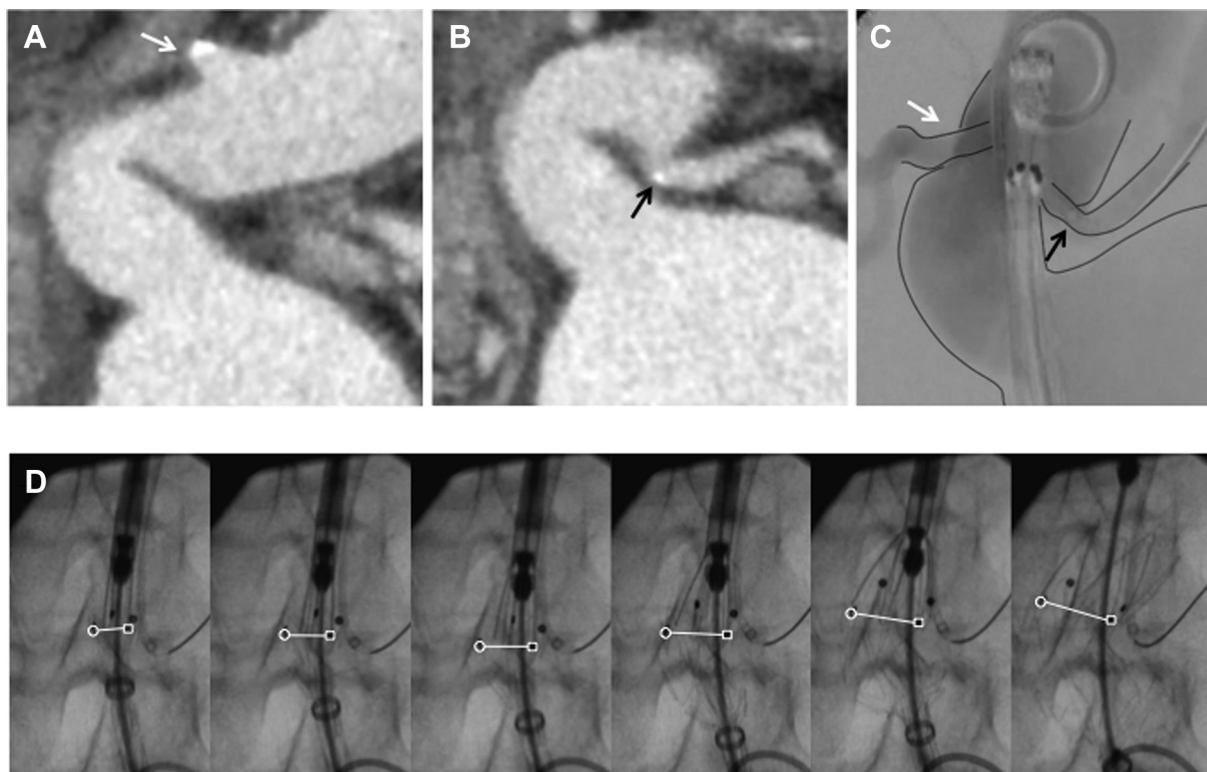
Deployment of the Endurant stent graft with the reverse slider technique in the angulated neck case (case 1). A and B, Preoperative three-dimensional computed tomography images show a severely angulated neck at 130 degrees with neck length of 25 mm. C, Angiography during the procedure. The Endurant delivery system runs on a shortcut. It touches the lower left renal artery in the lesser curvature side. D, A series of photographs until the suprarenal stent release. The top edge of the graft fabric on the greater curvature side is deployed and kept in the upper position. The *open circles* indicate the e mark stitched on the graft fabric edge. Each *open square* indicates the o mark stitched on the contralateral side of the e mark. As the top edge of the graft fabric expands, the e mark on the greater curvature side rises upward to a proximal position. The line between the e and o marks leans upward to the aortic axial. *White arrow*, right renal artery; *black arrow*, left renal artery.
